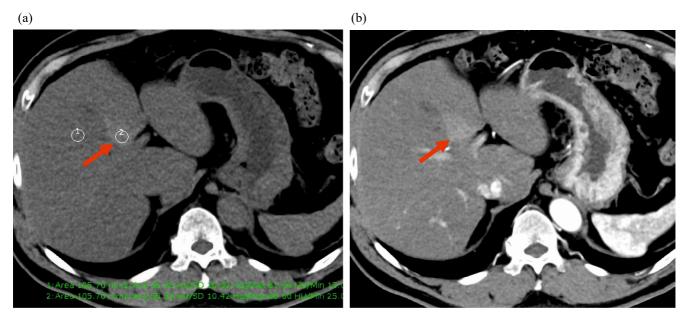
A 63-year-old man with diffuse hepatic steatosis accompanying a focal fatty spared area. a) Unenhanced CT shows a relatively hyper-attenuating focal area in the posterior aspect of the left medial segment (arrow). CT attenuation values of the focal spared area and the right hepatic lobe were 53.5 and 36.7 HU, respectively. b) Arterial-phase CT. Contrast enhancement value of focal fatty spared areas was higher than that of the areas of hepatic steatosis.
